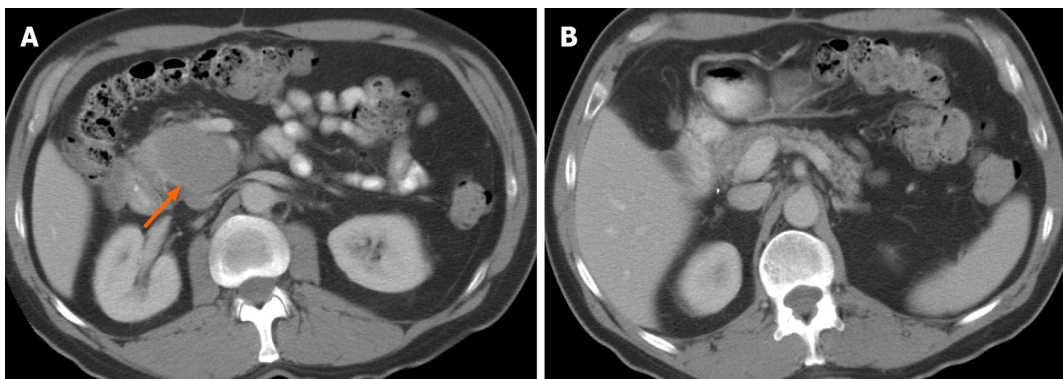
A 58-year-old male with abdominal pain. A: Axial computed tomography images demonstrate a large, relatively well-defined focal mass (arrow) involving the uncinate process of the pancreas; B: Axial computed tomography images. The tumor shows homogenous hypoenhancement, without evidence of any necrosis or calcification. The rest of the pancreas is preserved, and there is no pancreatic ductal dilation. Biopsy confirmed diagnosis of primary pancreatic lymphoma.
